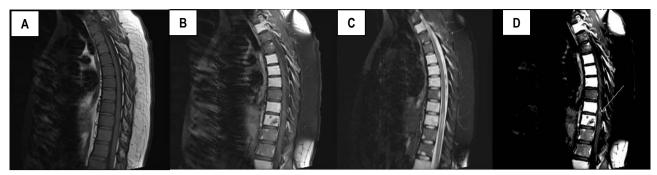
(A,B,C and D) Multiplanar multi sequences MRI imaging of the spine including post gadolinium sequences: Diffuse abnormal infiltrative patchy low T1/ high T2 marrow signal intensity associated with abnormal patchy enhancements involving the anterior and posterior vertebral body elements. Also, there is minimal amount of abnormal paraspinal and epidural thickening enhancement identified at thoracic and sacral region and causing moderate right T9-10 and left S2-3 neural foraminal narrowing. Neoplastic infiltration is highly suggestive. No evidence of pathological fracture or spinal canal narrowing. Non-expansile high T2 intra-medullary signal change identified extending form T9-10 to T10-11 level, with minimal parenchymal atrophy and questionable nodular enhancement. Furthermore, there is questionable tiny nodular enhancement at the cauda equina nerve roots at S1-2 level. Intrathecal infiltration would be considered.
